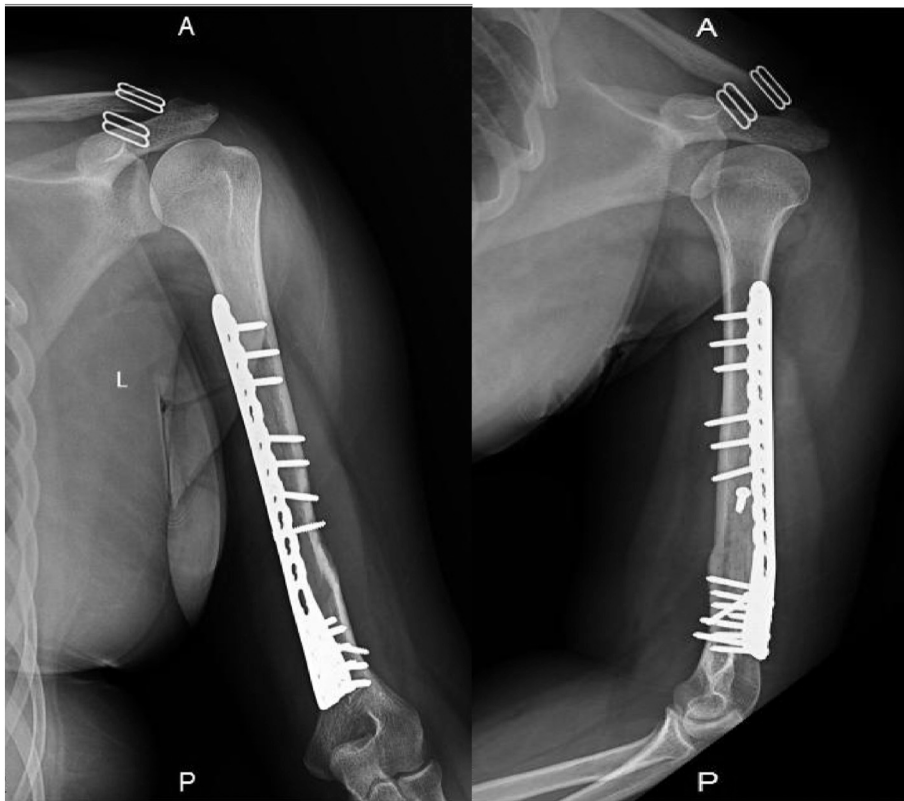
Radiographs at 4-months follow-up showing complete bony union with satisfactory alignment.
